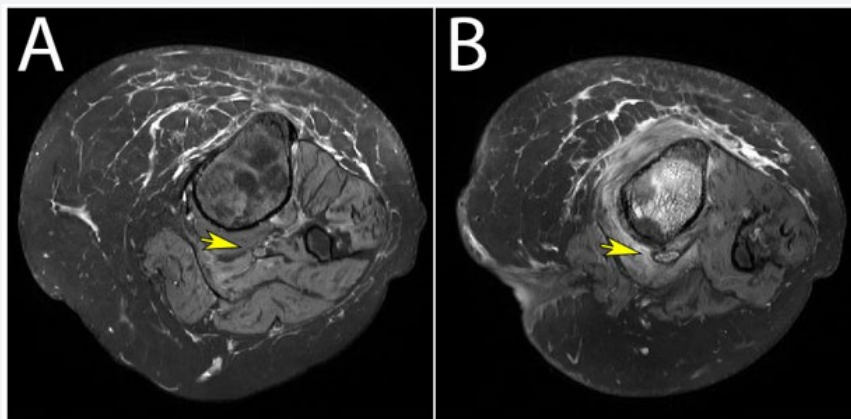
A. Proximal View of Left Lower Extremity on MRI Cross-Section with Tibial Nerve Neuroma (Yellow Arrow), B. Distal View of Left Lower Extremity and Tibial Nerve Neuroma (Yellow Arrow).
